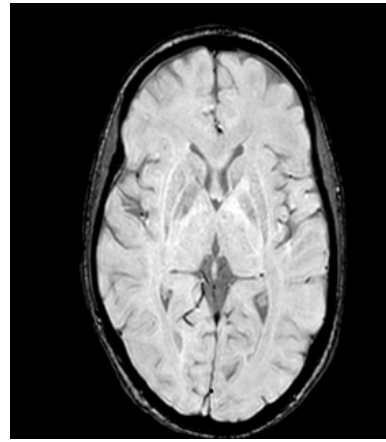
MRI showing, Axial susceptibility-weighted image (SWI) shows blooming in the basal ganglia and thalami, indicating copper and associated iron deposition.
